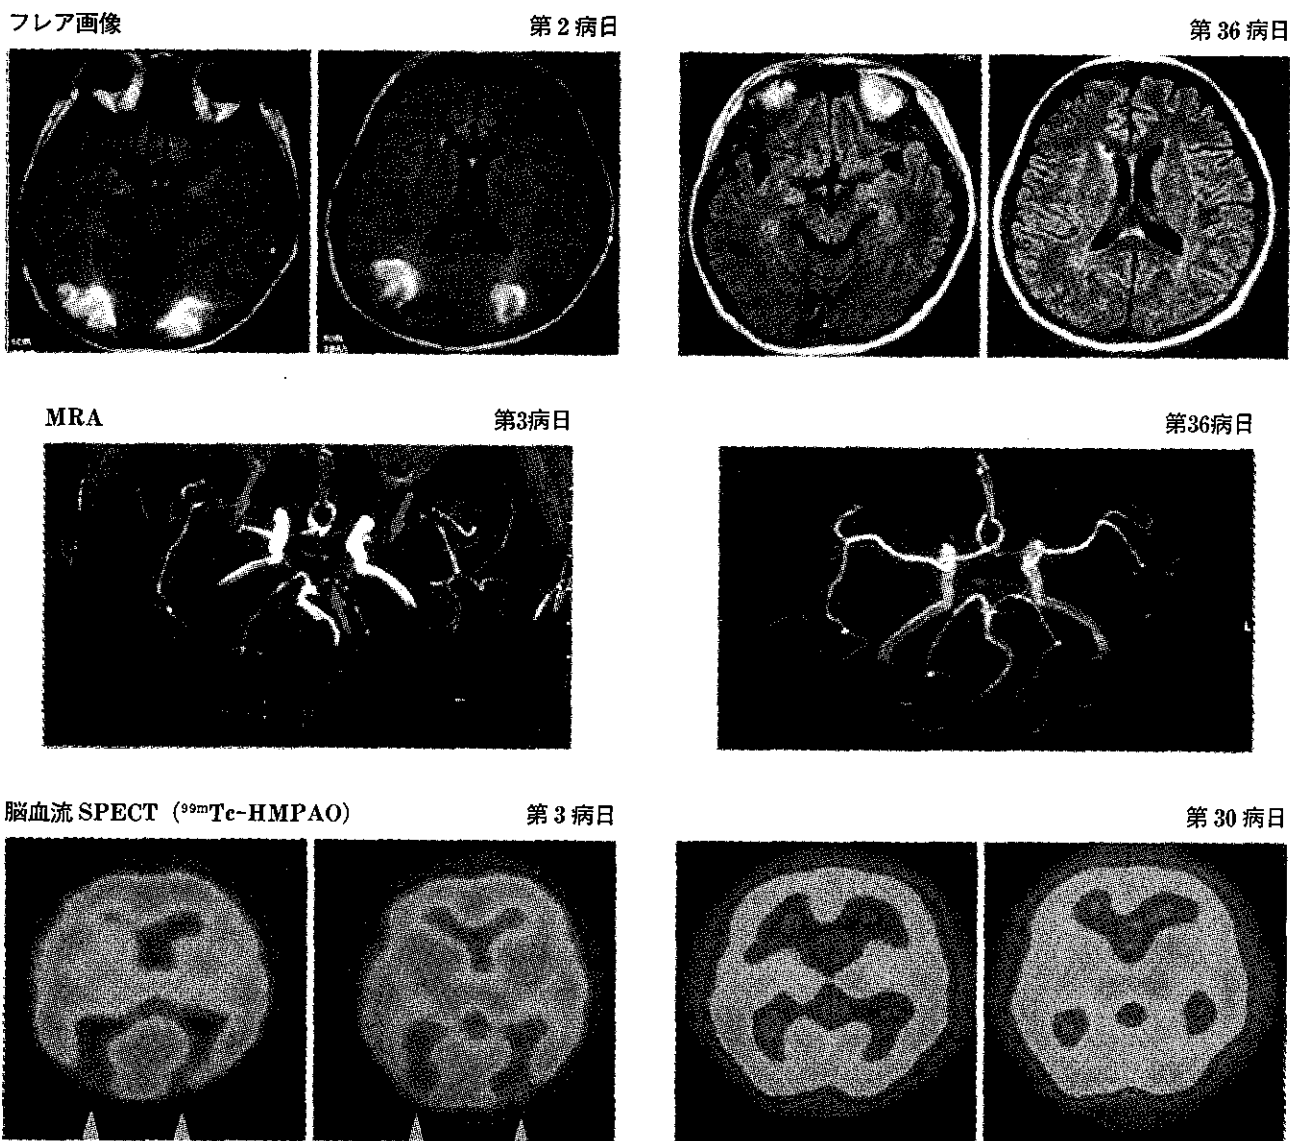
フレア画像 (上段), MRA (中段), 脳血流 SPECT (下段, ^{99m}Tc -HMPAO) の経時変化
